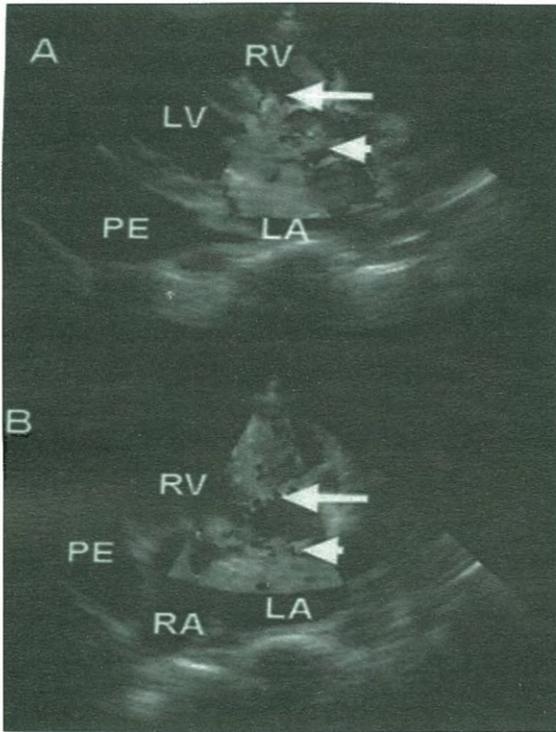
Color flow imaging in the parasternal long-axis view (A) and short-axis view (B) demonstrate left-to-right shunting across the ventricular septal defect (arrow) and reveal turbulent flow through the aorta-left atrial fistula from the aorta to left atrium (arrowhead). LV: left ventricle, LA: left atrium, RV: right ventricle, RA: right atrium, PE: pericardial effusion.
